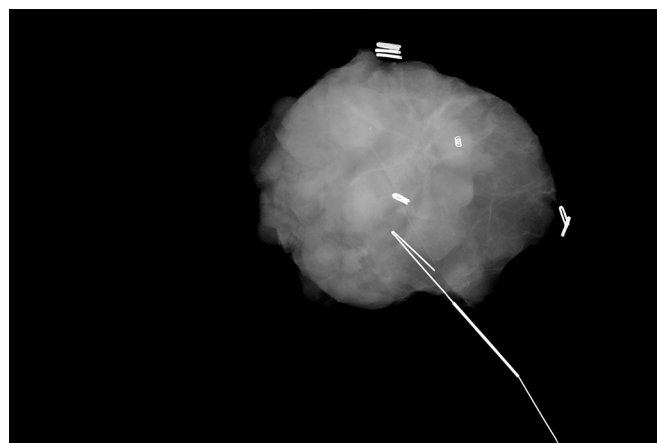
Intraoperative radiograph with wire and coil deployed confirming the completeness of excision.
